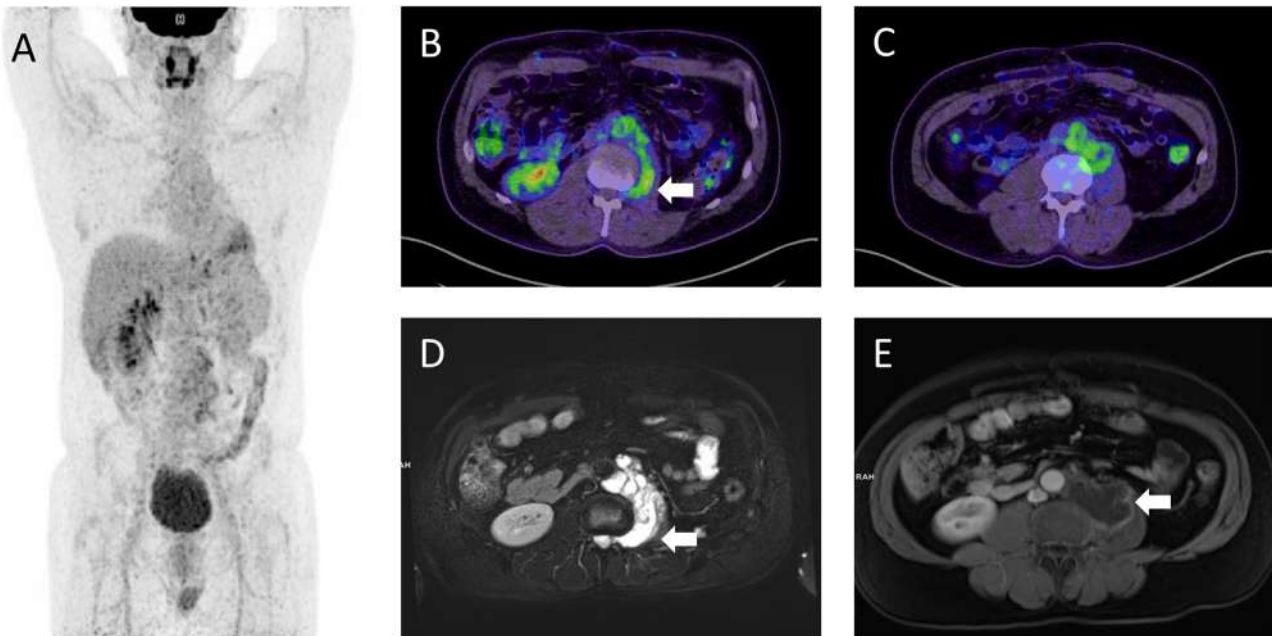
^{18}F -FDG PET/CT shows a para-aortic retroperitoneal mass of $6 \times 8 \times 12$ cm (extending from L2 to L5), with a mild tracer uptake (SUVmax 5) (arrow in B). On MRI, this mass is hyper-intense in T2 (arrow in D) and hypo-intense in T1 and with a peripheral contrast-enhanced (arrow in E), moreover, there is an apparently infiltration of L2 left neural foramen. There was no evidence of other sites of disease.
